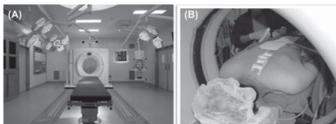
(A) The CT scan moves on fixed rails. The 3D optical LED localizer as well as the Vector Vision navigation screens are ceiling mounted. (B) Scout CT being performed with fiducial skin markers to localize the lesion level.
